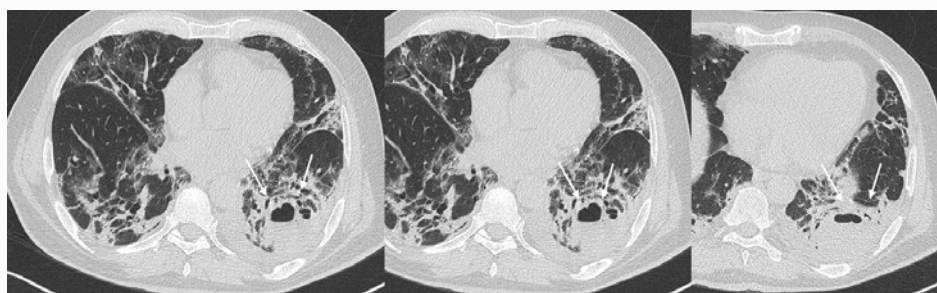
Axial thin-sections unenhanced CT scan show organizing pneumonia areas with diffuse alveolar damage, subpleural opacities with thickening of bronchial segmentations and sub-segmentations and concomitant traction bronchiectasis and in lower left lobe an excavated area up to 4 cm in maximum diameter (arrows).
